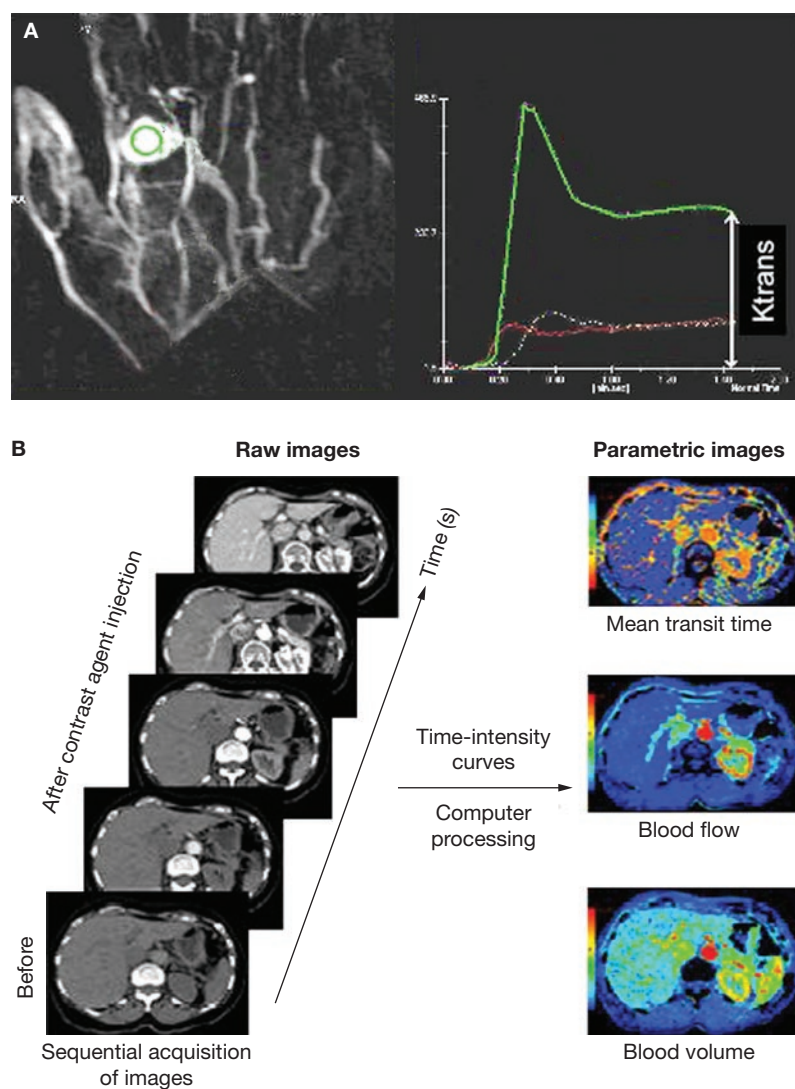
Dynamic contrast-enhanced MRI and dynamic contrast-enhanced CT of a hypervascular tumor. (A) Dynamic contrast-enhanced MRI of a hypervascular tumor, located in the right hand. The left panel represents the raw data image with the regions of interest for determining the time-intensity curves. The right panel shows the time-intensity curves: the green curve represents tumor perfusion, with a strong enhancement of the arterial phase, a plateau due to extravascular diffusion of the contrast agent, and slight increase due to the recirculation of the contrast agent (second pass); the red curve and the white curve represent the arterial and venous references, respectively. K^{trans} can be estimated after recirculation of the contrast agent and represents vascular permeability. (B) Dynamic contrast-enhanced CT. After sequential acquisition of the raw images over time (left panels), the time-intensity curves of the different perfusion parameters can be obtained for each pixel of the images or any regions of interest. Parametric images representing time-intensity values for each pixel over time will be calculated from these curves (right panels). (Images courtesy of Dr J-Y. Meuwly, CHUV, Lausanne).
